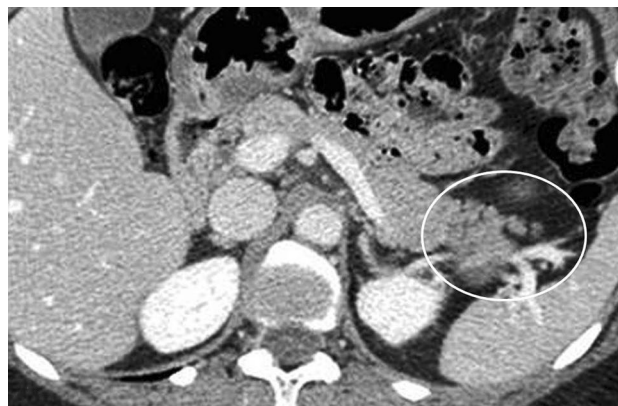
Axial CT image in 41-year-old man shows small pancreatic cleft which is the invagination of fat into the pancreas (*circle*)
